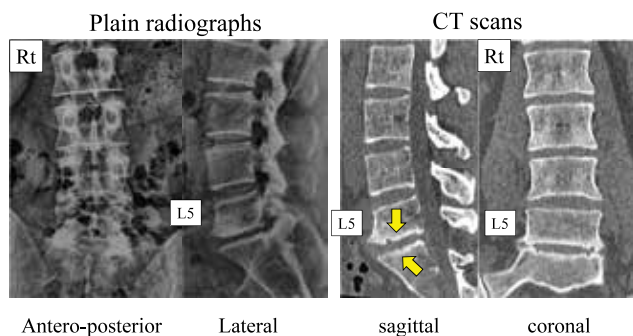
Plain radiographs and CT scan before surgery
